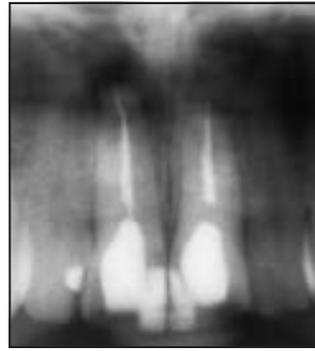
Radiographic examination revealed a periapical lesion, subsequent to prior root canal therapy. The alveolus was intact, and the periodontium was healthy.
